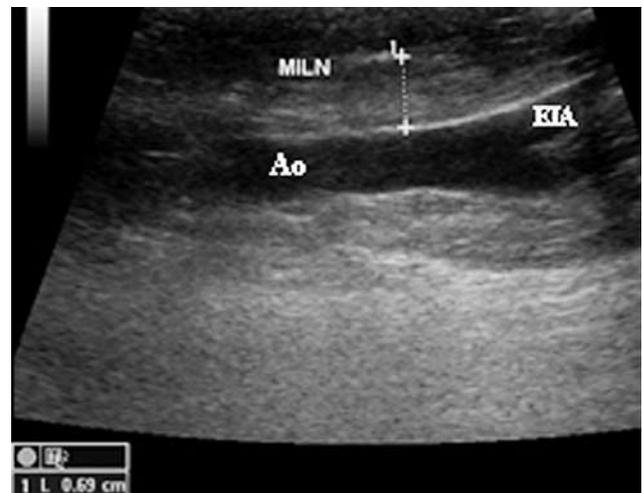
Longitudinal ultrasound image of a normal canine medial iliac lymph node. Ao = aorta, EIA = external iliac artery, MILN = medial iliac lymph node.
